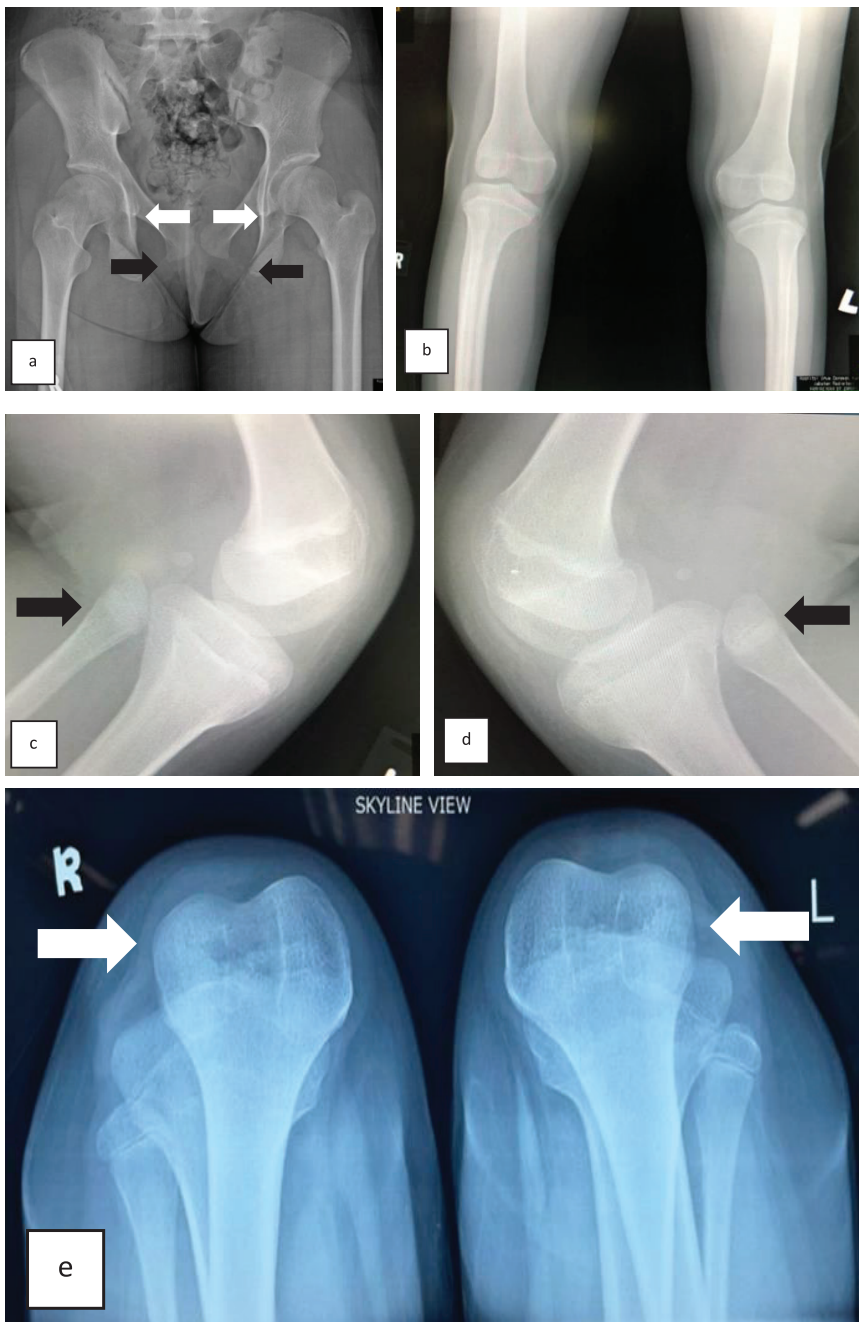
(a) Anteroposterior plain radiograph of the pelvis demonstrates absence of the ossification of bilateral ischiopubic junction (black arrow) and presence of infra-acetabular axillary cut notches (white arrow) (b) Bilateral genu valgus is shown from the anteroposterior view of the knee radiograph (c), (d) lateral views of right and left knee show missing patella, different sizes of the condyles of the femur and dysplastic epiphysis of the proximal fibula (black arrow) (e) skyline view of the knee demonstrate absent of patella and smaller lateral condyle of the femur (white arrow).
